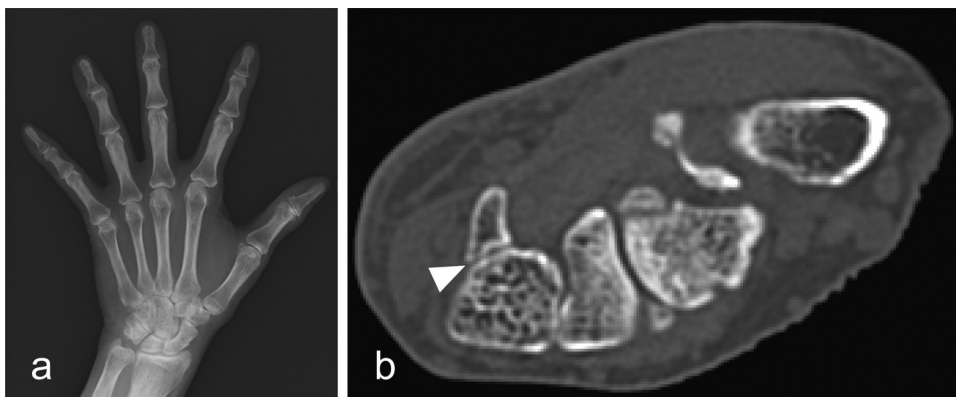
(a) Plain X-ray image (b) CT image (arrow head: nonunion of the hamate hook).
